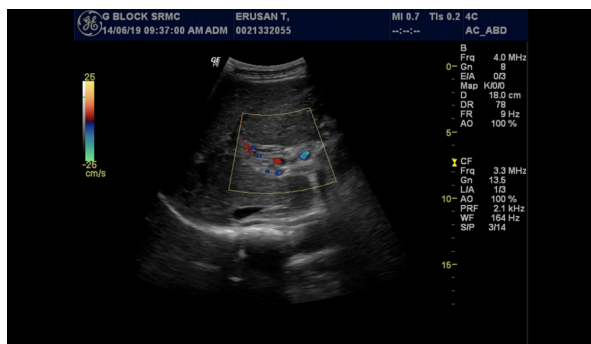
ultrasound image of chronic portal vein thrombosis
